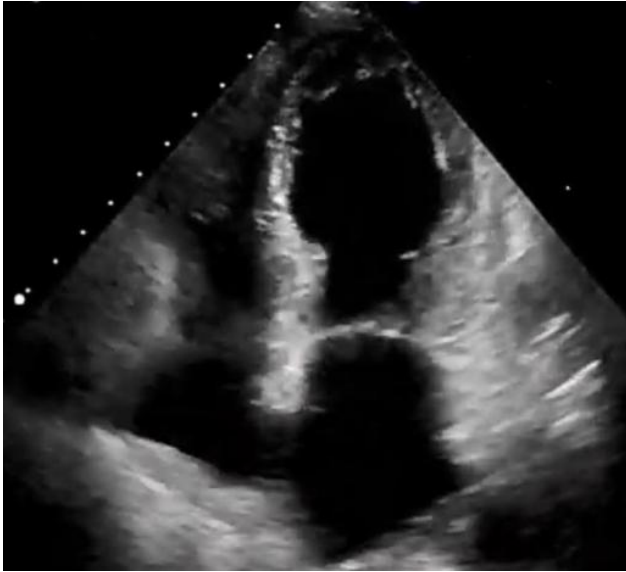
Echocardiography with wide apical akinesia
